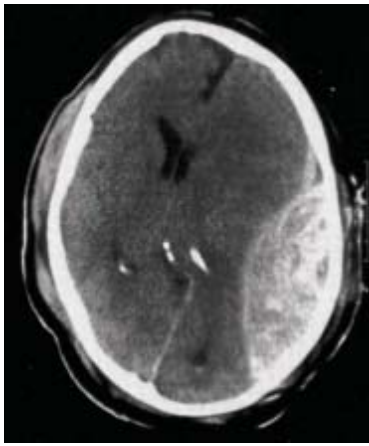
Computed tomography of head of a patient with a left-temporal epidural hematoma. Note the profound midline shift.
